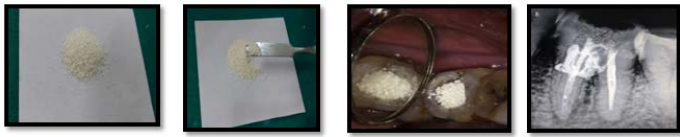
(a) Dispensing of egg shell powder (b) use of cement carrier for placing egg shell into the pulp chamber; (c) intraoral picture of egg shell being placed into the furcal perforation (d) Radiograph of egg shell being placed in to the furcal perforation.
